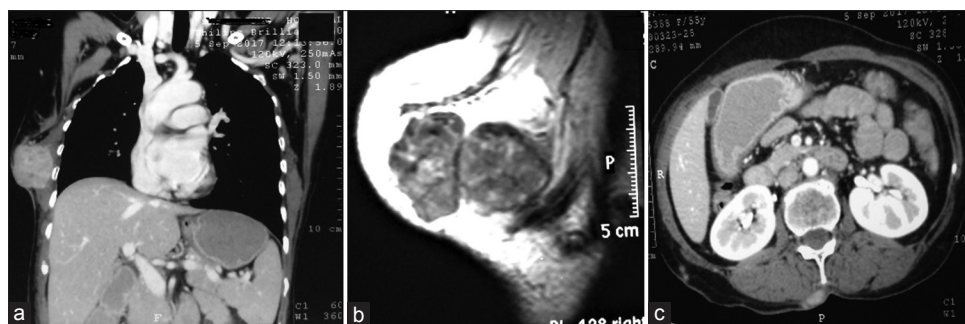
(a) Contrast-enhanced computed tomography scan of the thorax and abdomen revealed well-defined, intensely enhancing heterogeneous mass lesion in the right posterolateral chest wall (coronal view), (b) contrast-enhanced magnetic resonance imaging of the right breast revealed large-lobulated, intensely enhancing, well-defined mass lesion in the right breast, and (c) few subcutaneous metastatic deposits in the right lower back
